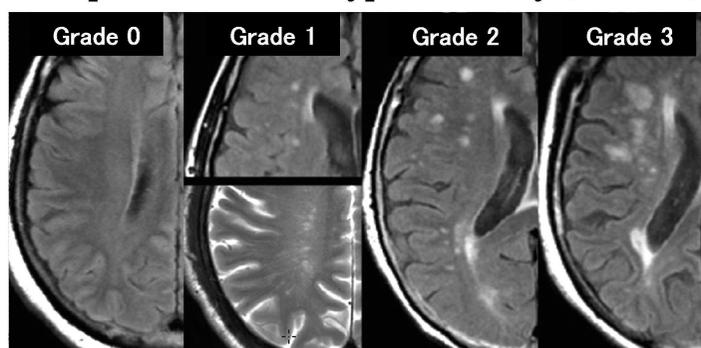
PVH and DWMH grading of magnetic resonance images
